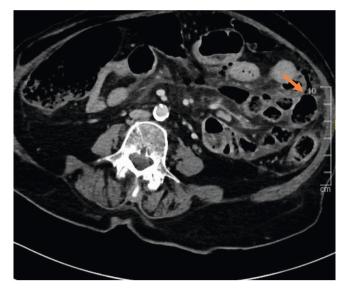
Axial CT abdomen; showing focal defect at the left ileal segment communicating with extensive foci of multiple free air pockets.
